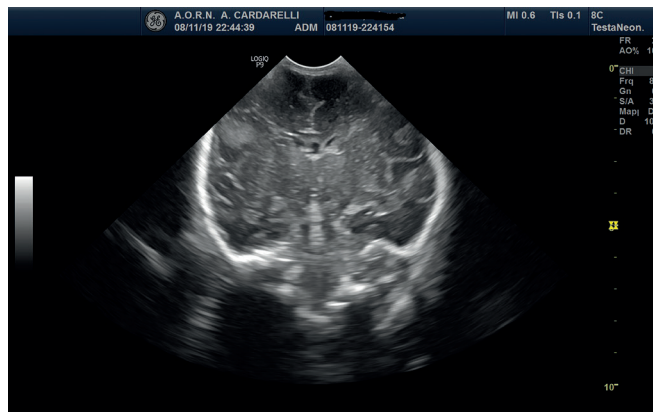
Cerebral ultrasound.
